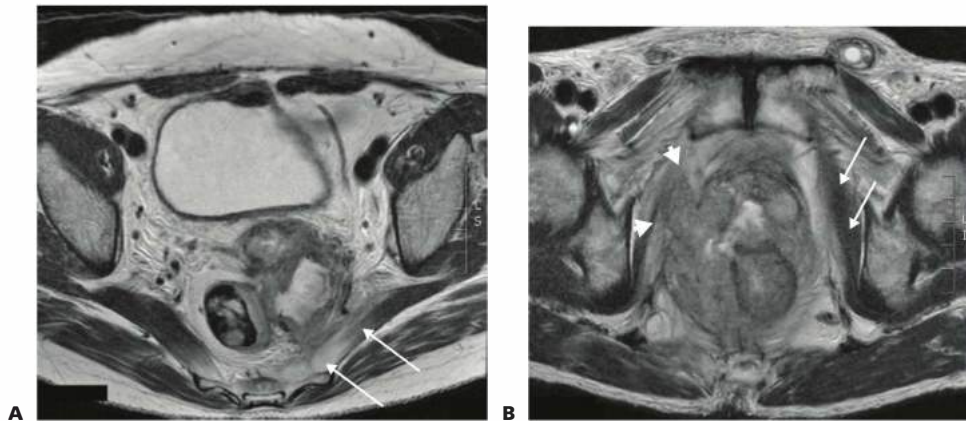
• A. MRI of the pelvis showing locally advanced cervical cancer. The cancer is seen to the left of the rectum and is invading the left piriformis muscle (arrows). This patient has pain in the left S2-S3 nerve root territory consistent with sacral plexus infiltration. B. MRI of the pelvis of a patient with a large LACC abutting the left obturator internus muscles (arrows) and directly infiltrating the right obturator internus muscle (arrowheads).
